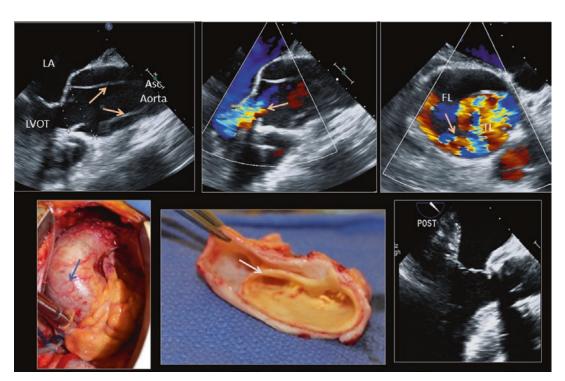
Images from a patient with ascending aortic dissection. Top left: The longitudinal view depicts the intimal flap (arrows) that originates in the aortic root; the aortic ring is of normal size but aorta is dilated immediately above the ring level; Top middle: Severe aortic regurgitation is noted (arrow); Top right: Color Doppler shows the true lumen with flow and the arrow points to the entry site;
